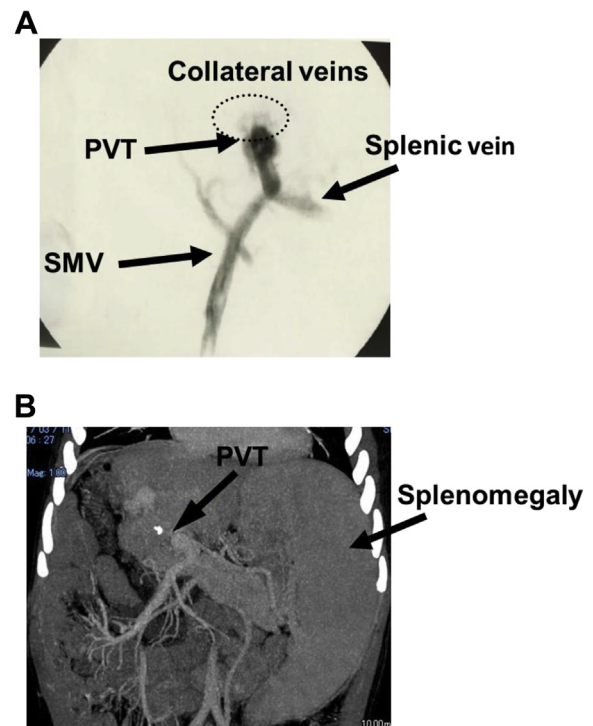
Portographic (A) and abdominal computed tomographic (B) images of case 2, taken 3 years after liver transplantation. Abbreviations: PVT, portal vein thrombosis; SMV, superior mesenteric vein.
